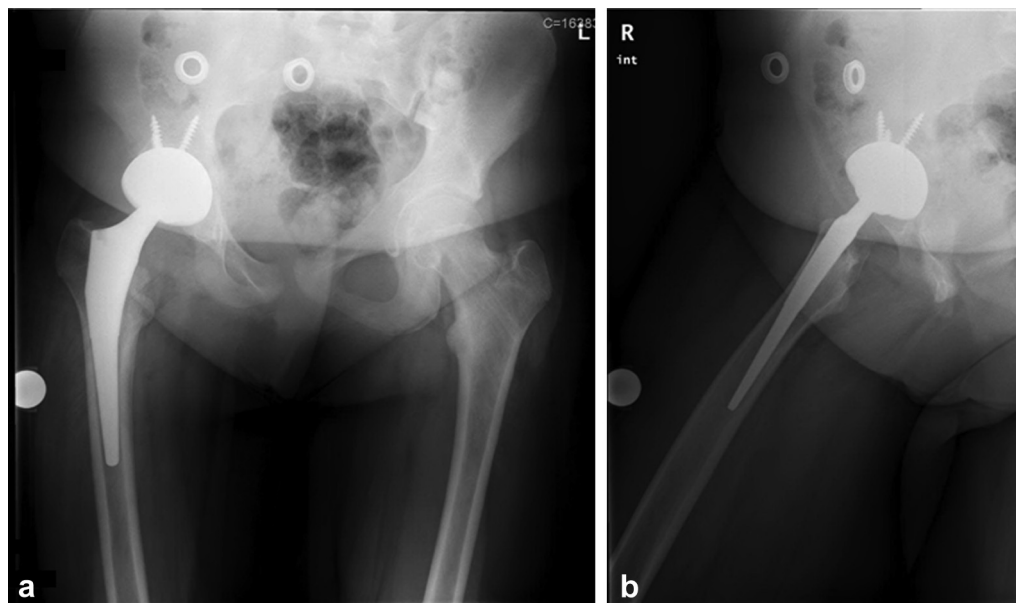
AP pelvis (a) and frog lateral (b) radiographs showing the components to be in appropriate position.
